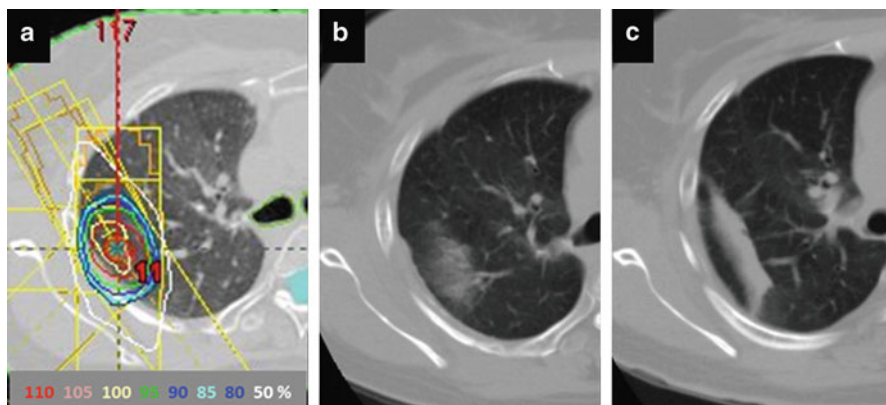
Post-SBRT radiation fibrosis considered scar-like pattern. (a) Isodose distribution prescribed with 48 Gy in 4 fractions at isocenter, (b) CT image at 3 months after SBRT, (c) CT image at 24 months after SBRT
